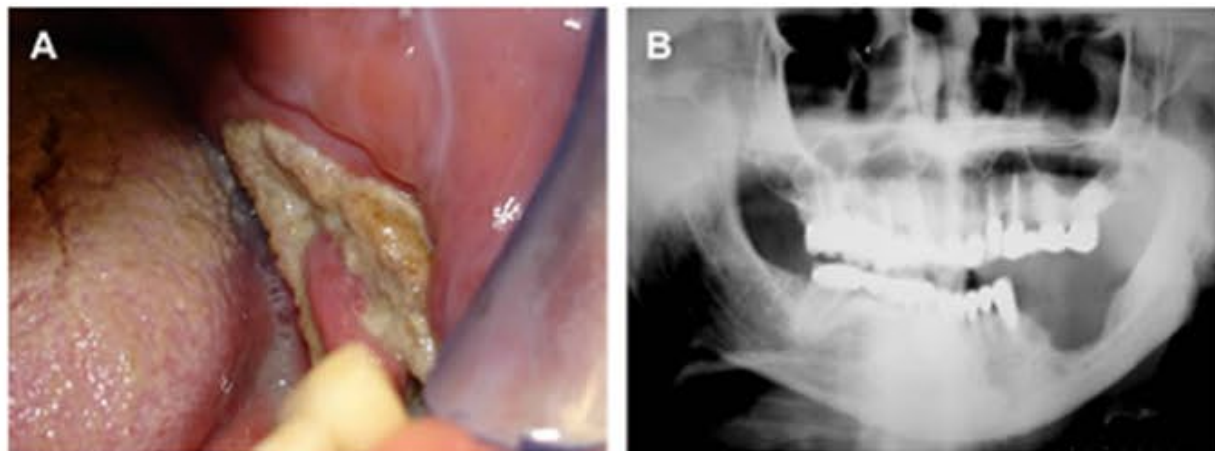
(A) Post-radiation osteonecrosis of the left mandible. (B) Panoramic radiograph showing postradiation osteonecrosis of the left mandible.
